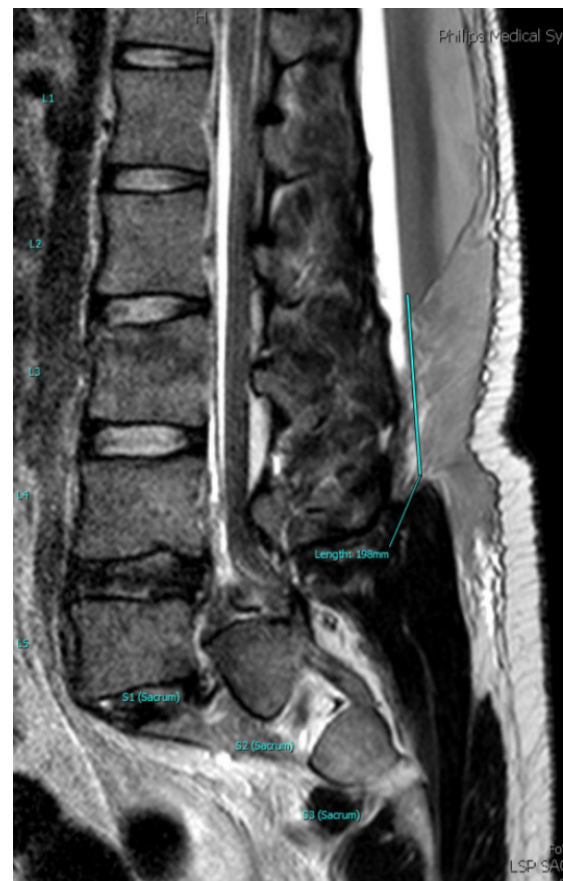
Sagittal T2 sequence magnetic resonance imaging redemonstrating L3 AO Spine (AOS) B2 fracture and L5 AOS C fracture.
